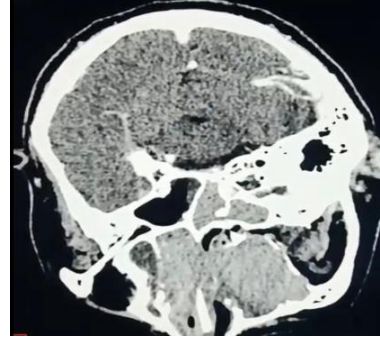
CT image of tumor in sinonasal region
